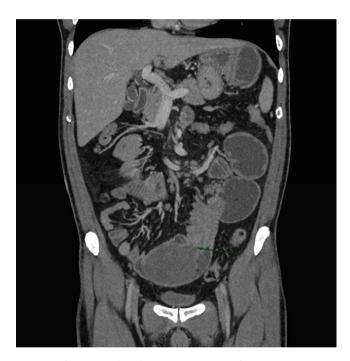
Coronal CT showing intussusception from case #9.
